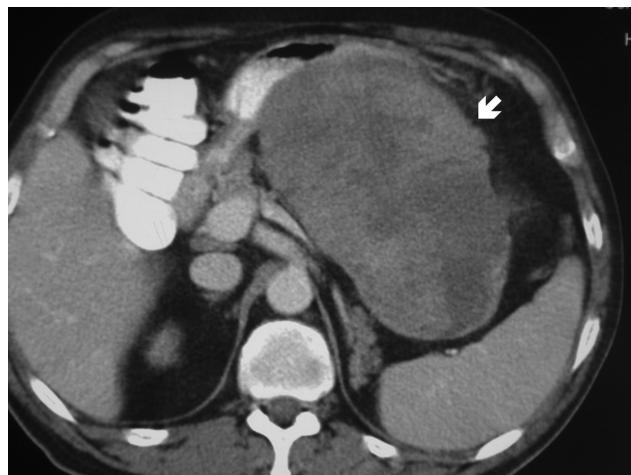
Post-contrast CT scan shows large primary tumor (white arrow).
